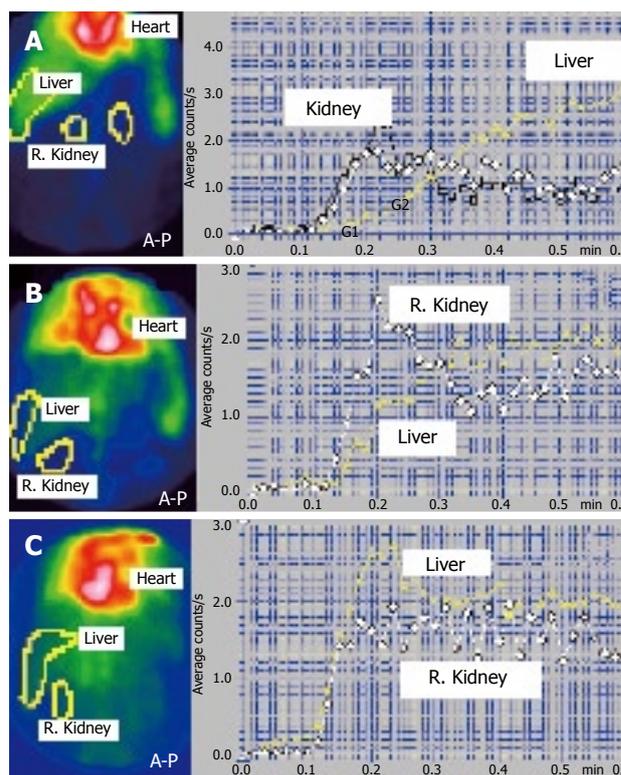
Liver angioscintigraphy. A: Normal aspect. HPI = 30%. G1 = arterial inflow segment; G2 = portal inflow segment; B: Cirrhotic patient. HPI = 60%; C: Cirrhosis with reversed portal flow. HPI = 130%.
